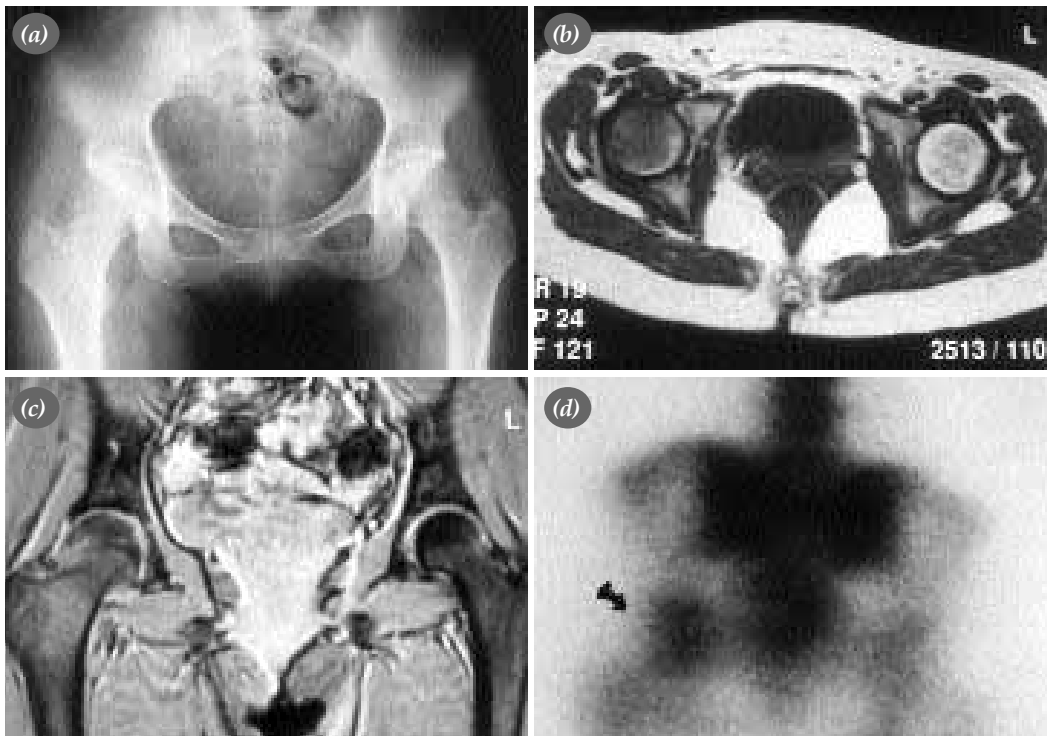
In case number one, (a) standard antero-posterior view showed osteopeny and demineralization in the femoral head and neck; while MRI revealed effusion, and (b) change in signals as decrease in T_1 -weighed sequences and (c) increase in T_2 -weighed sequences. (d) The entire body bone scintigraphy showed increased homogeneous density in the proximal femur.
